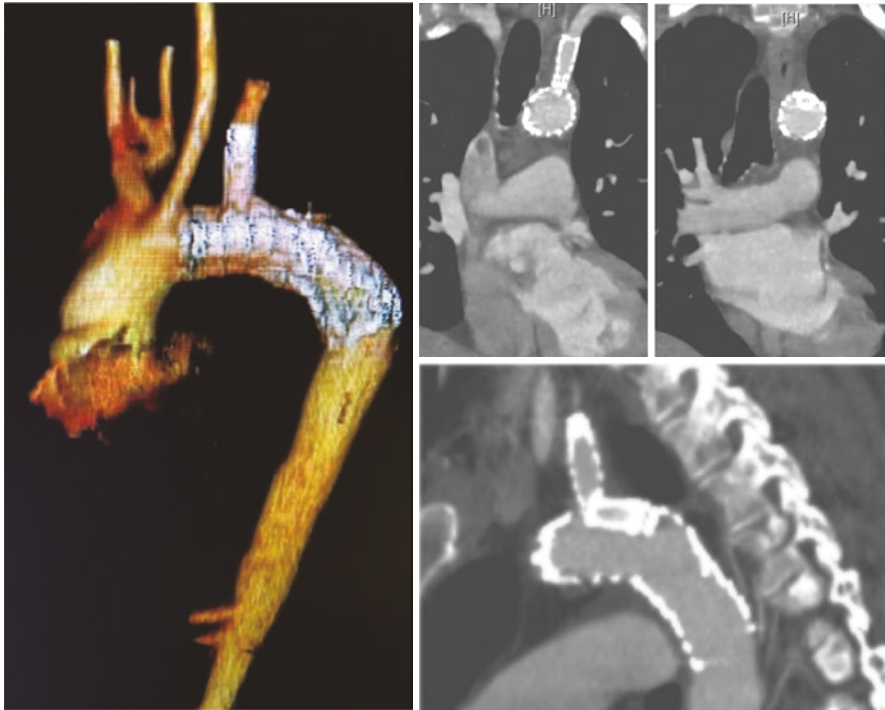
A selection of images from a CTA of the chest obtained 3 months after treatment of a blunt thoracic aortic injury with a branched endograft. These images demonstrate excellent aortic remodeling and no endoleak
